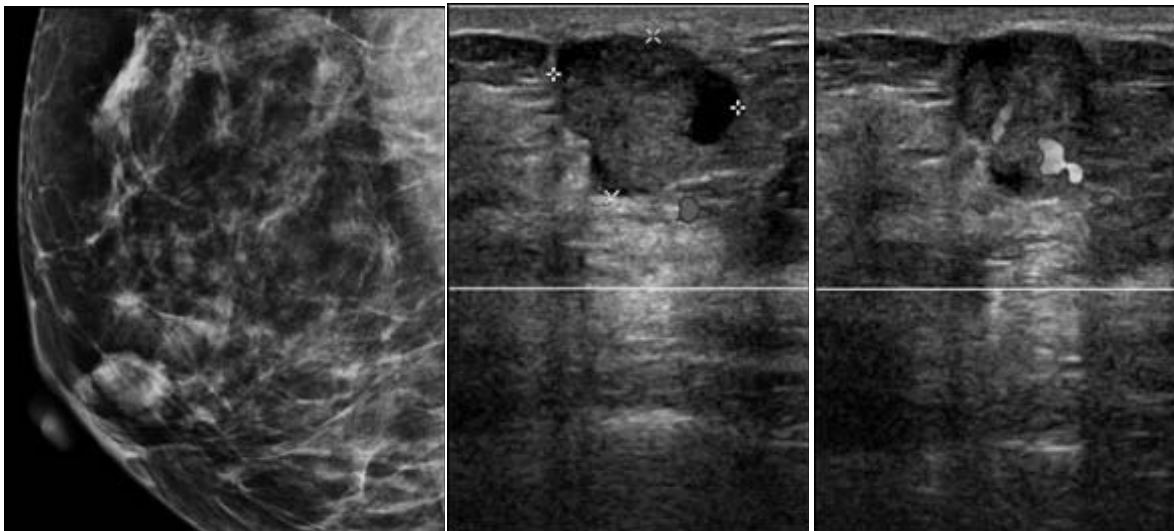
A 48-year-old female presented for check-up. (Right) Mammography revealed a circumscribed oval isodense mass at subareolar area of right breast. (Middle and left) As for sonography, this mass showed a complex cystic-solid echo, posterior enhancement and vascularity in solid component. Excision confirmed intraductal papilloma.
